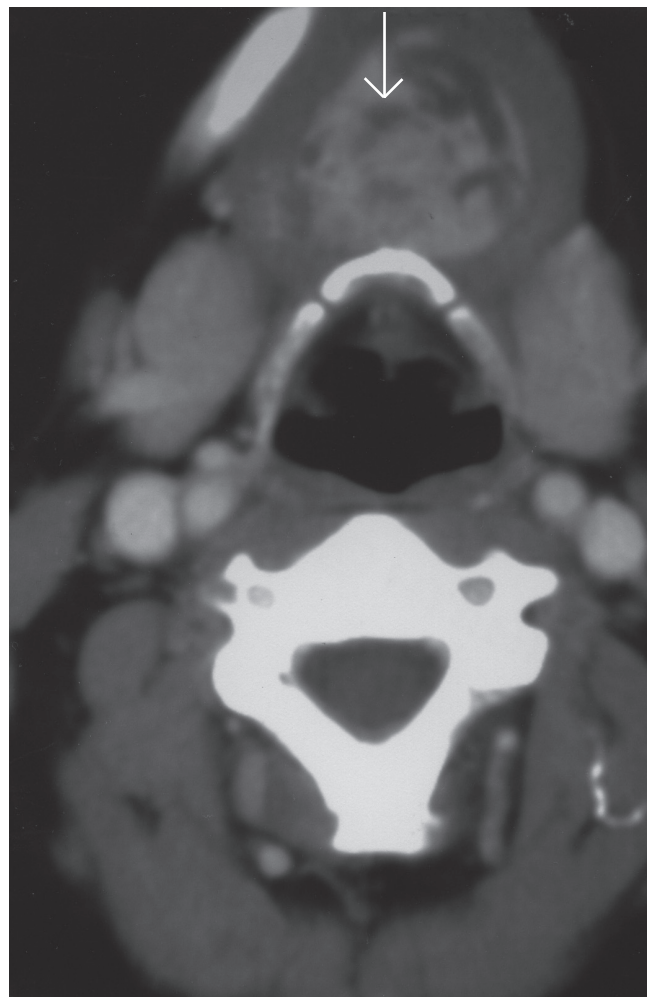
Axial CT scan of the neck showed a well-circumscribed midline neck mass anterior to the hyoid bone with the same enhancement characteristics as normal thyroid (arrow – ectopic thyroid tissue).
